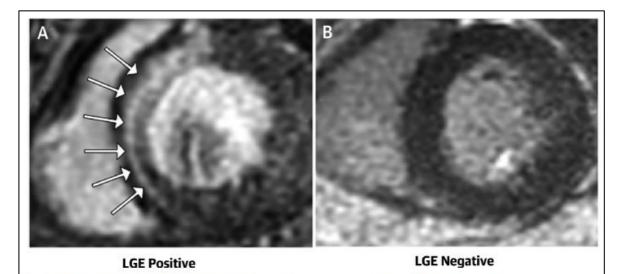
Late gadolinium enhancement indicative of myocardial fibrosis as demonstrated on cardiac MRI (white arrows)
